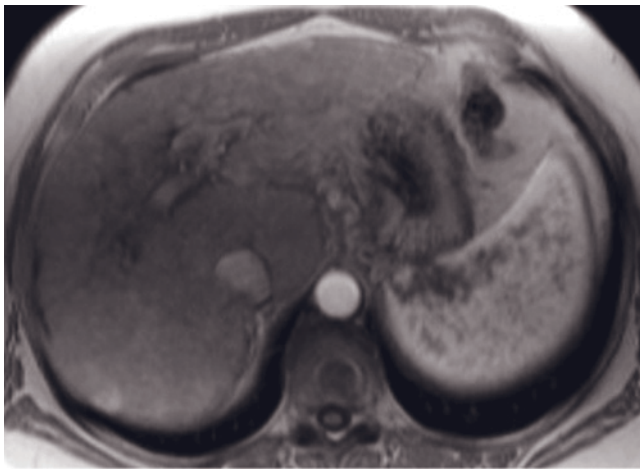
(Continued) SS-ETSE (e), SGE (f), and immediate (g) and 90-s fat-suppressed (h) images; and T2-weighted SS-ETSE (i), out of phase SGE (j), and immediate (k) and 90-s fat-suppressed (l) images in three patients with hepatitis C in different stages. Prominent porta hepatis lymph nodes are usually present (e).
